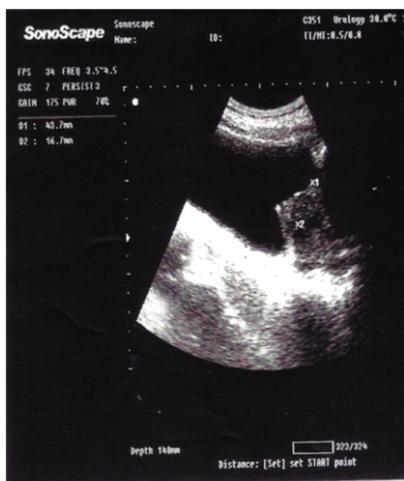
Midline sagittal sonographic scan image, showing how to measure IPP; perpendicular height (line 2) from the line drawn across the base of the bladder (line 1).
